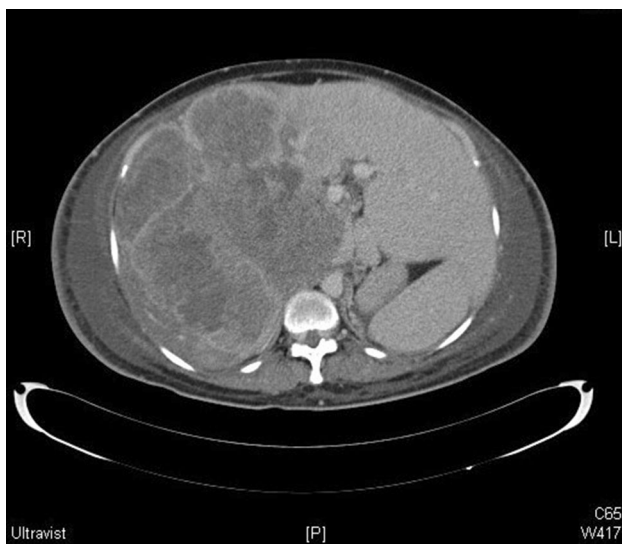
CT Scan Axial C reveals a large liver mass occupying the entire right hepatic lobe extending medially to segment IV
